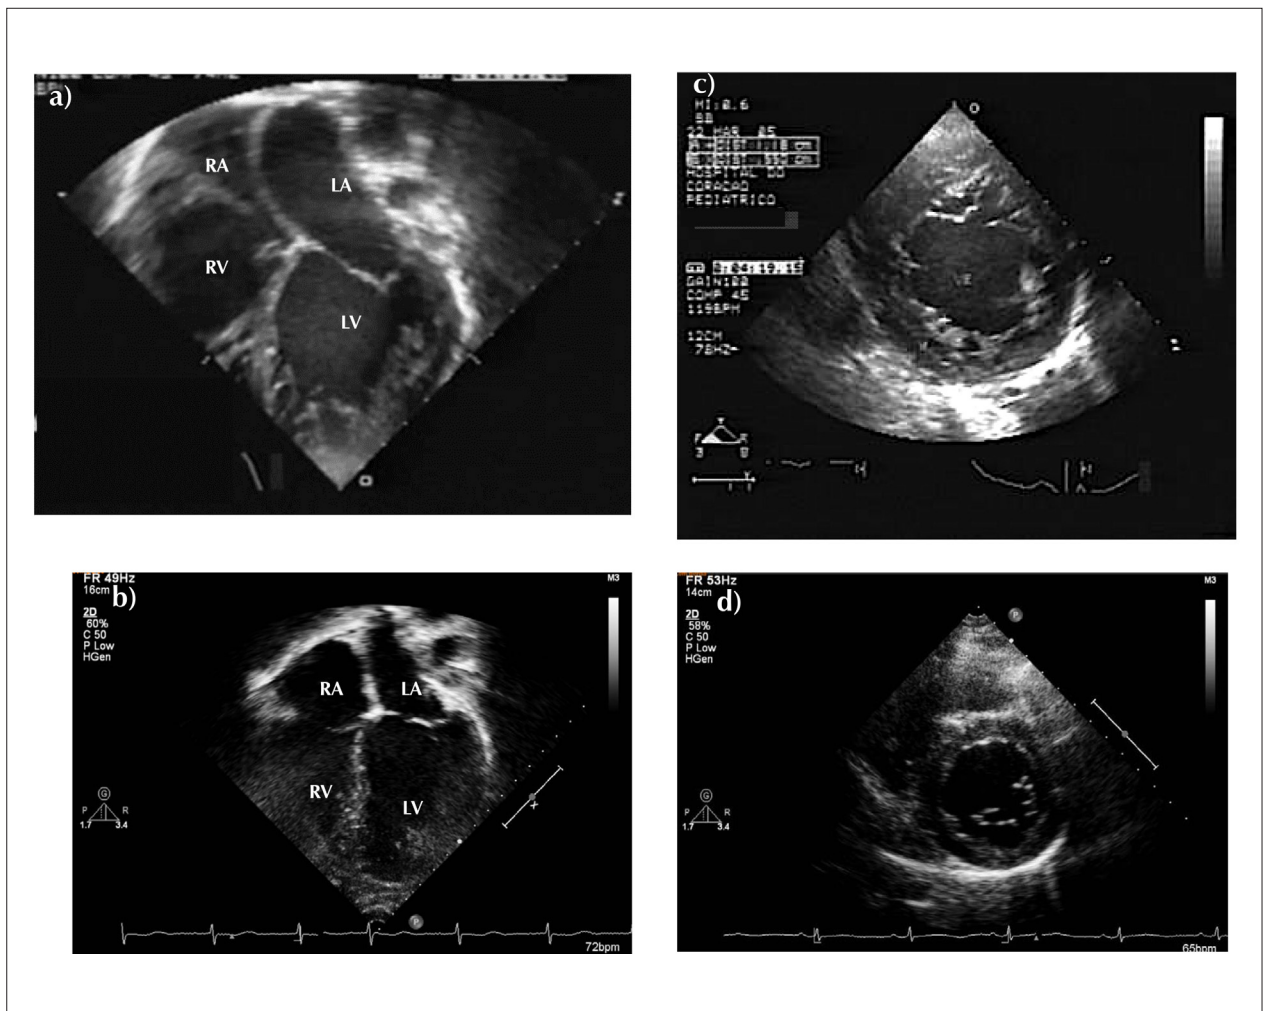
Echocardiographic study performed at the age of 6 years shows dilated left chambers, spongy left ventricle, and noncompacted to compacted myocardium ratio of 3.2:1, long axis plane (A) and short axis plane (C), and after 7 years of clinical drug treatment (B and D).
